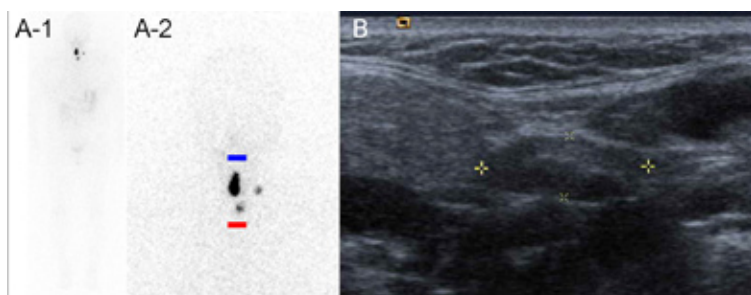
First surveillance for recurrence performed 9 months after total thyroidectomy for papillary thyroid cancer. A-1 and A-2: Diagnostic radioiodine whole body scintigraphy and its magnified image focused on neck (Blue bar indicates location of chin and red bar indicates location of sternal notch.), obtained 24h after oral administration of 185MBq ^{123}I , revealed 3 foci of uptake in the anterior neck. Two foci were located at the midline of the neck and one focus was located at the left lateral neck area. However, B: US of the neck showed normal lymph nodes on both sides of the neck. There was no abnormal lesion or lymph node on the midline of the neck on the US.
